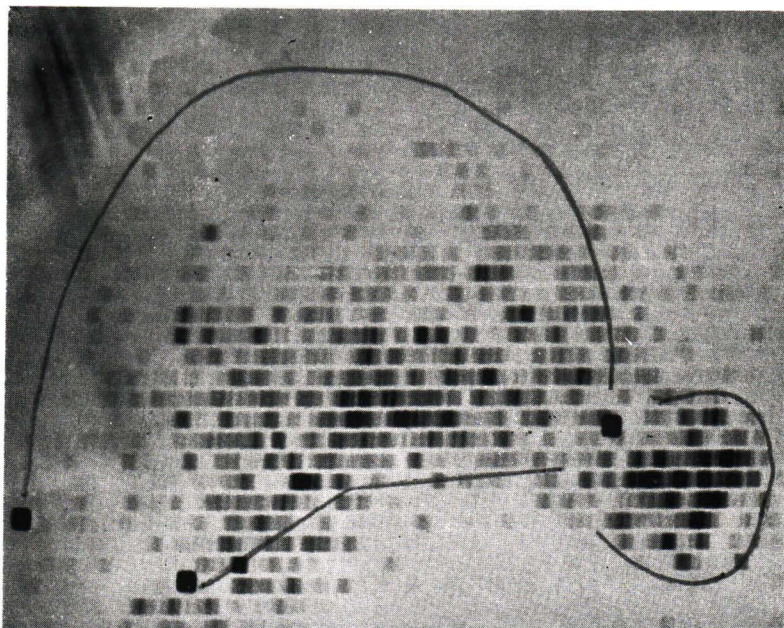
Lateral scintigram after intrathecal injection of ^{131}I -RISA showing the extension of subarachnoid space into the sac of sincipital encephalomeningocele.
